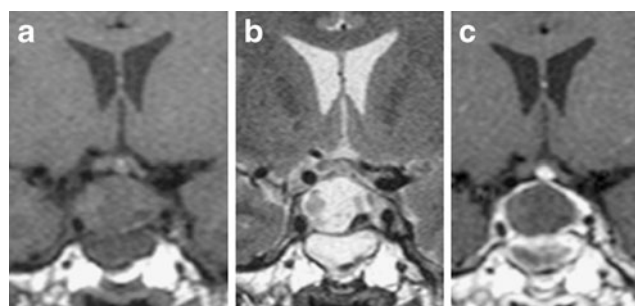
Coronal MR imaging of case 1 showing an intrasellar cystic mass with suprasellar extension, which appears isointense on T1-weighted images (a), and of mixed intensity on T2-weighted images (b), and it displays rim enhancement along the cyst wall following gadolinium injection (c)
